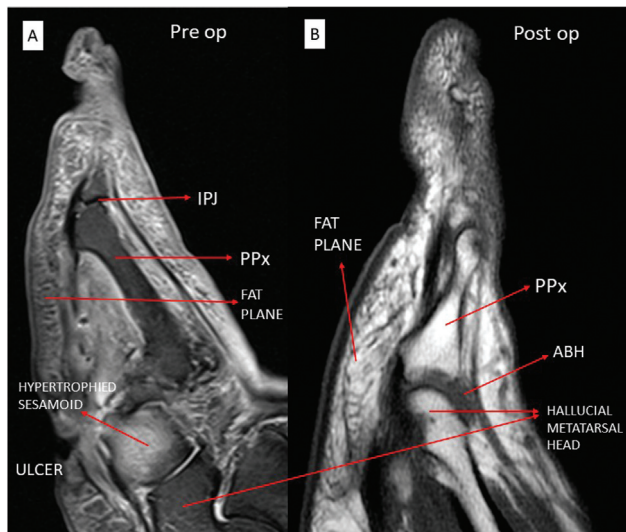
(A, B) Sagittal view of preoperative and postoperative magnetic resonance imaging along the axis of hallucial metatarsophalangeal joint (MTPJ) showing good retention of fat in the plantar aspect of ball of great toe (B). Maintenance of abductor hallucis (ABH) muscle mass around the joint restoring the congruent position of hallucial MTPJ, (B) when compared with preoperative image (A). IPJ, interphalangeal joint
